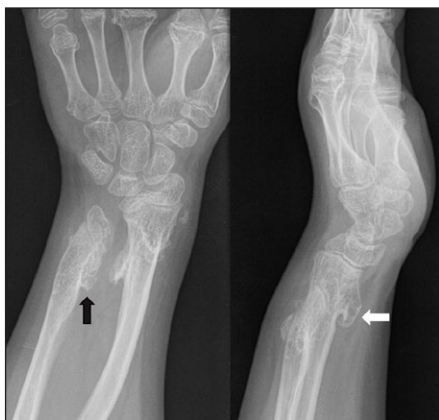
Cauliflower, coathanger, trumpet-shaped deformities in a patient with Hereditary Exostosis Syndrome. Plain radiograph of the left wrist showing shortening of the ulna, pseudo-Madelung deformity of the wrist and multiple exostosis. The exostosis on the distal radius has a long stalk and therefore resembles a coathanger (white arrow), whereas the exostosis on the ulna has a broad insertion on the cortex resembling a mushroom or cauliflower (black arrow).
